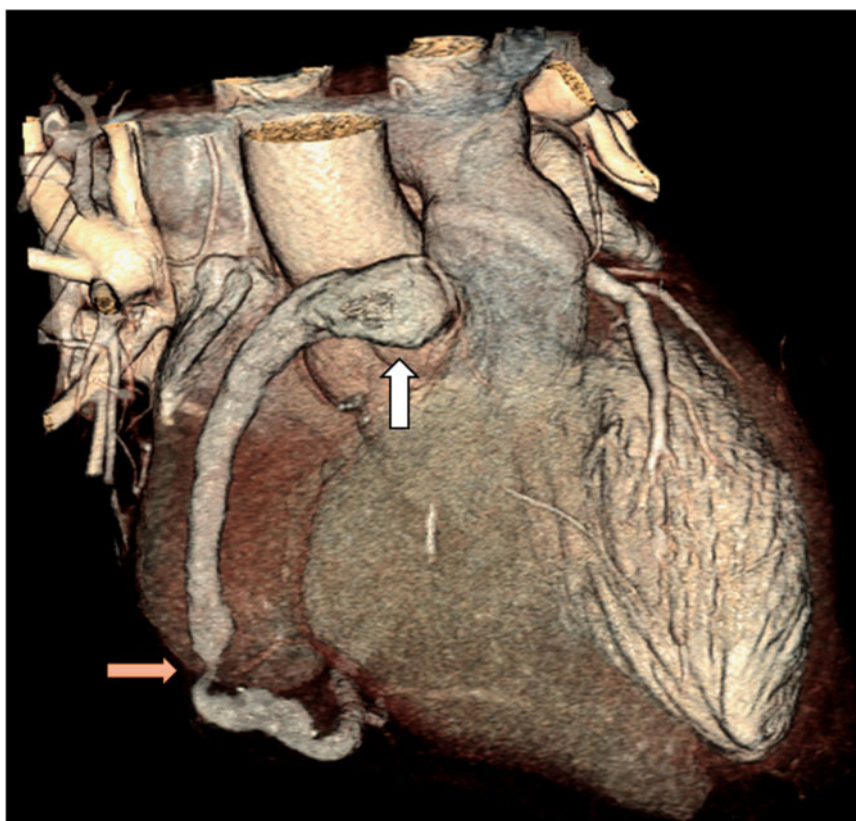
Volume rendered CT image showing the same structures than *Figure 1* with dilatation of the proximal part (white arrow) and severe distal stenosis (red arrow).
